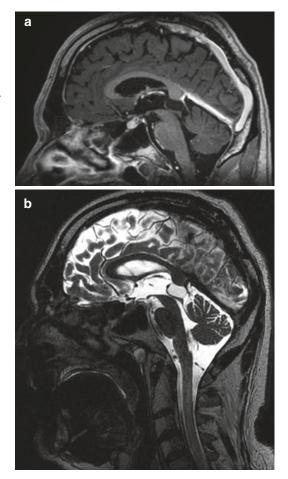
(a, b) Sagittal T1+ contrast and T2 MRI sequences in a 54-year-old male who presented with morning generalized headache and diplopia. Imaging shows a PC with a diameter of about 2 cm, with the slight distortion of the Sylvius aqueduct. Nevertheless, a thorough neurological examination diagnosed the patient with myasthenia gravis with complete remission of symptoms following medical treatment.
